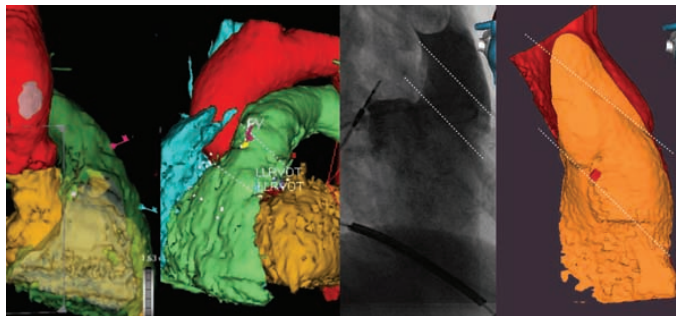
This figure is in four sections with the left two sections showing a 3D reconstruction from a multislice CT in right lateral and then LAO views, showing how the RVOT (in green) curves around the left ventricular outflow tract (in yellow) and aorta (in red) such that the “septum” is not in a single “flat” plane as suggested by the angiographic image, but actually runs from the anterior RVOT inferiorly to the posterior RVOT superiorly. The course of the RVOT is highlighted by the dotted lines in the three images on the right. The impression of the aorta can also be seen on the virtual endoscopic view on the far right.
